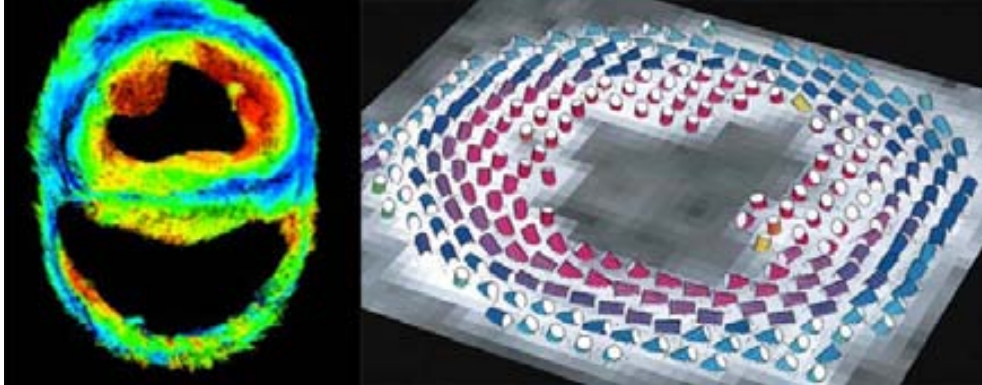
2D (left) and 2.5D (right) representations of principal eigenvector directions in DT-MRI data in its application to cardiac description. Figures adapted from [125, 119].
